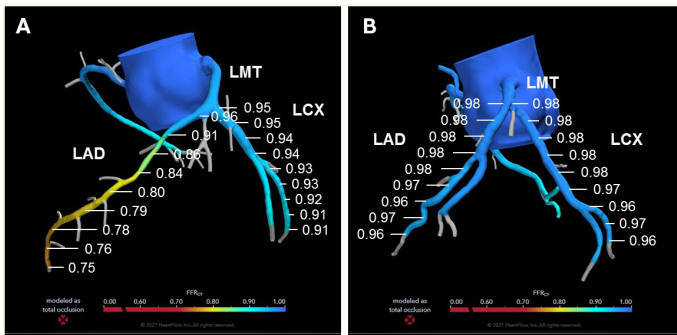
Computed tomography angiography derived fractional flow reserve (FFR_{CT}). (A) Case 1: FFR_{CT} is 0.96 at LAD just after the LMT-LAD-LCX bifurcation and decreases to 0.75 at its distal portion. FFR_{CT} is 0.95 at the LCX just after the LMT-LAD-LCX bifurcation and decreases to 0.91 at its distal portion. (B) Case 2: FFR_{CT} is 0.98 at LAD just after the LMT-LAD-LCX bifurcation and decreases to 0.96 at its distal portion. FFR_{CT} is 0.98 at LAD just after the LMT-LAD-LCX bifurcation and gradually decreases to 0.96 at its distal portion. LAD: left anterior descending; LCX: left circumflex; LMT: left main trunk.
